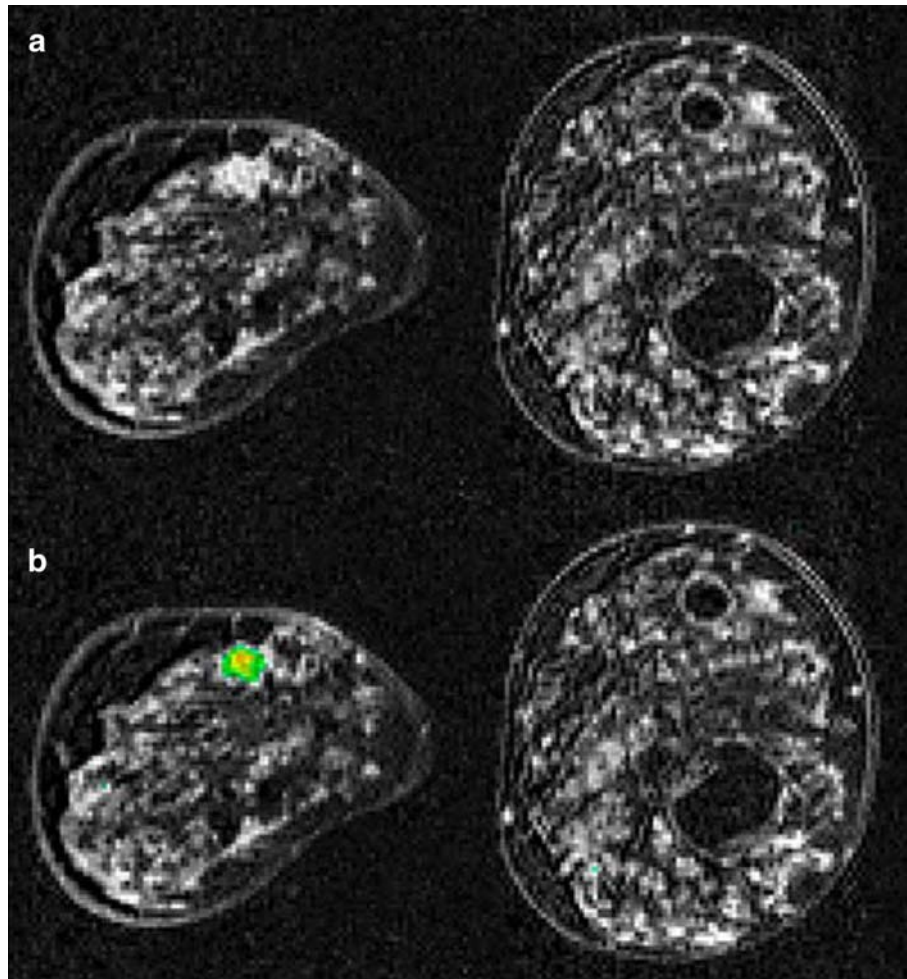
A 9-mm invasive ductal carcinoma at 12 o'clock in the right breast and distinctive partially enhancing fibrocystic changes in both breasts. a) shows the early subtraction image, b) the parametric overlay. The carcinoma is labelled whereas the multiple enhancing benign areas are not indicated with color-coded overlay. The patient was treated with breast-conserving therapy and radiation of the right breast. There were no signs of recurrent disease in the follow-up MRI 28 months later.
